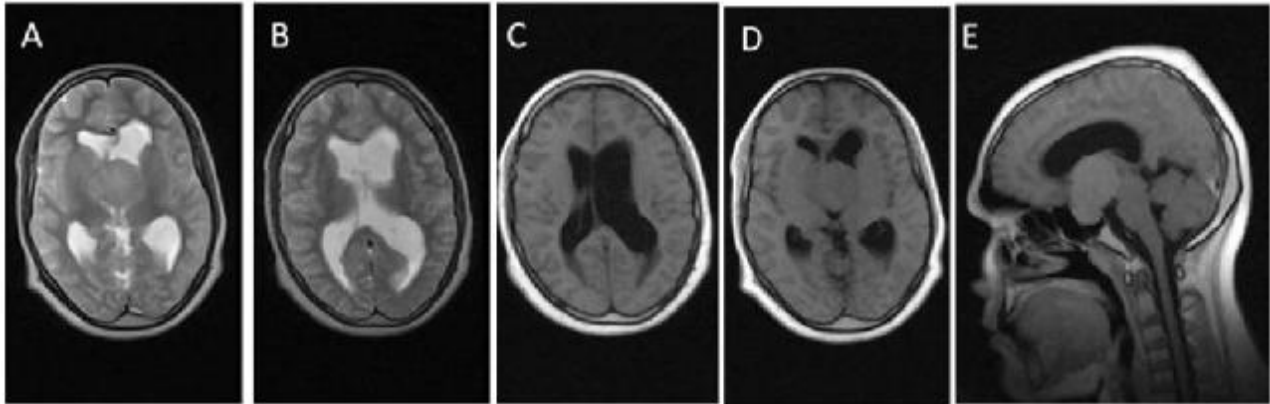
MRI of the brain showing a suprasellar meningioma causing hydrocephalus (A & B T2 axial views, C & D T1 axial views, E T1 sagittal view).
